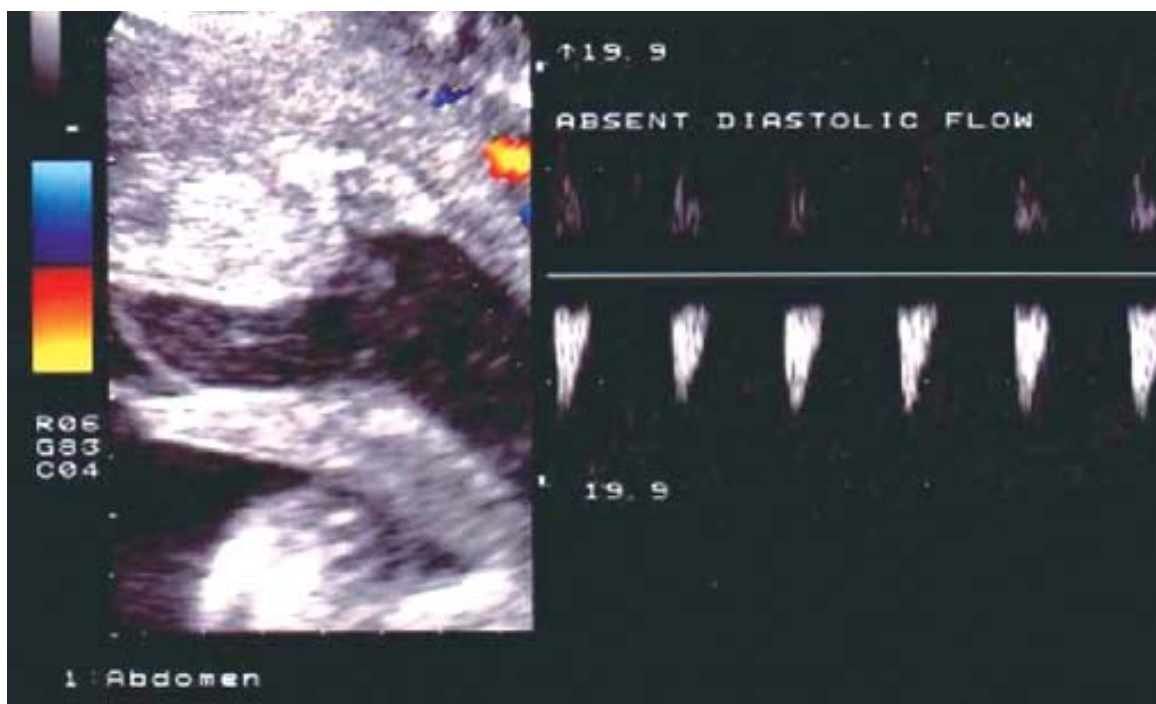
Transvaginal color Doppler scan of a hematoma. Note the absence of diastolic flow (RI = 1.0) detected in spiral arteries close to the perigestational hemorrhage
